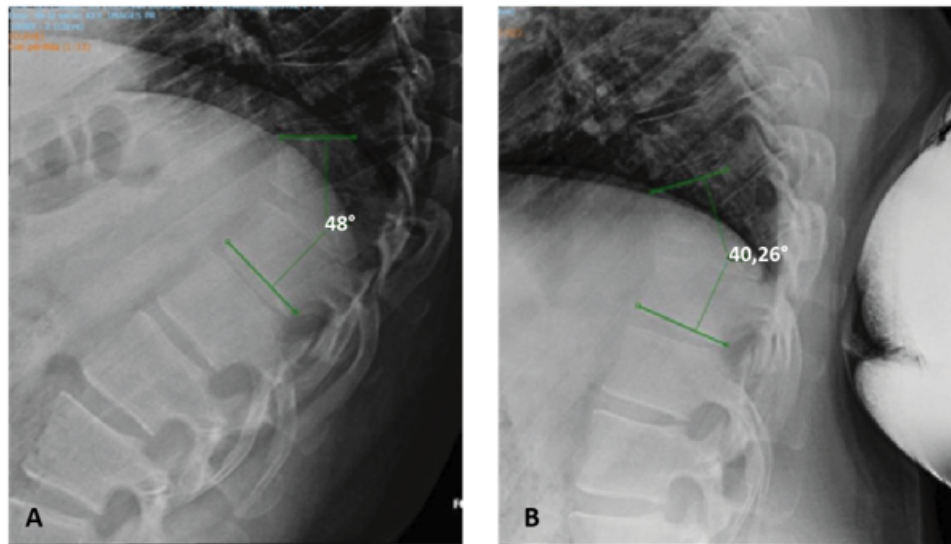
Focused pre-operative dynamic X-rays shows T9T11 kyphotic angle of 48° on flexion view (A) and 40° on extension view (B)
